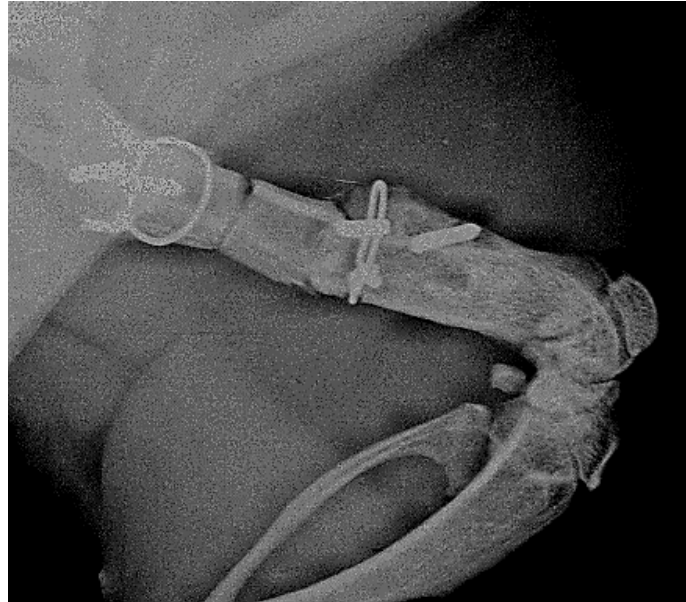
X-ray radiograph of the control allograft after 4 weeks of implantation. No healing or bone bridging is observed.
